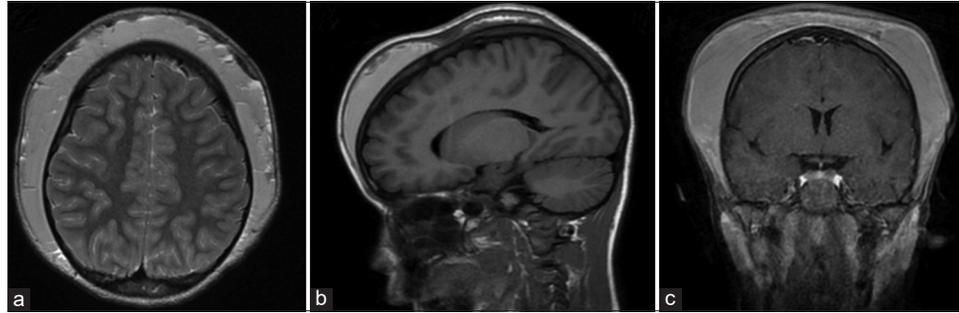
(a) Axial T2 MRI brain demonstrating bilateral subgaleal fluid collections, enlarged compared to noncontrast CT had a week prior, (b) sagittal T1 flair brain demonstrating collections along the frontal and parietal aspects of the calvarium, and (c) coronal noncontrast T1 MRI of the brain demonstrating bilateral subgaleal hematoma formation.
